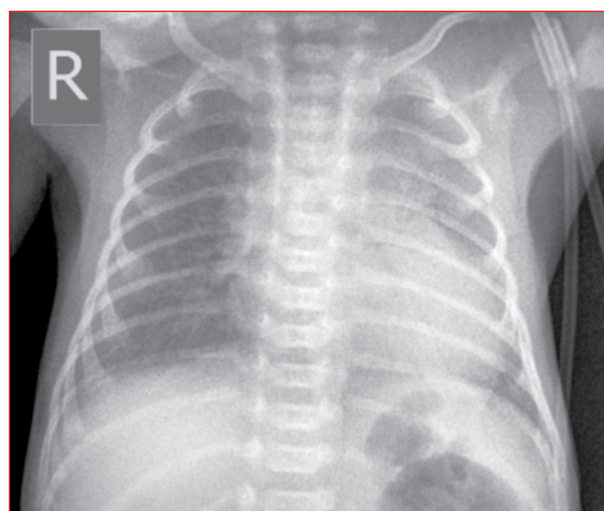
Ground-glass appearance on chest X-ray of a patient with hyaline membrane disease
